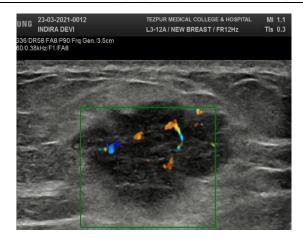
A 30-year female came with h/o nipple discharge and swelling in the breast. On USG a lobulated SOL having angulated margins was found at the upper inner quadrant of the right breast. Internal vascularity present on colour doppler. Report was given as s BIRADS 4a lesion. Biopsy revealed infiltrating ductal carcinoma.
